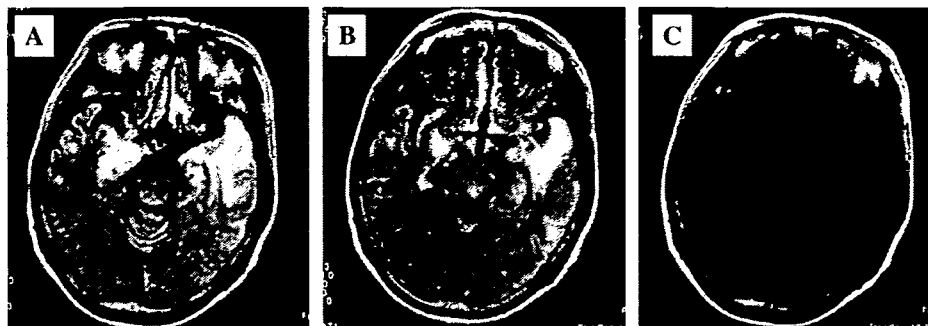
Initial MRI findings. FLAIR images demonstrate bilateral hyperintense areas in the hippocampus and parahippocampal gyrus, as well as a mass effect, especially on the left side. High signal intensity lesions are also present in the right insular cortex, as well as bilaterally in the frontobasal cortex and cingulate gyrus. (A, B) On T1-weighted image, the lesions were demonstrated low intensity. (C).
